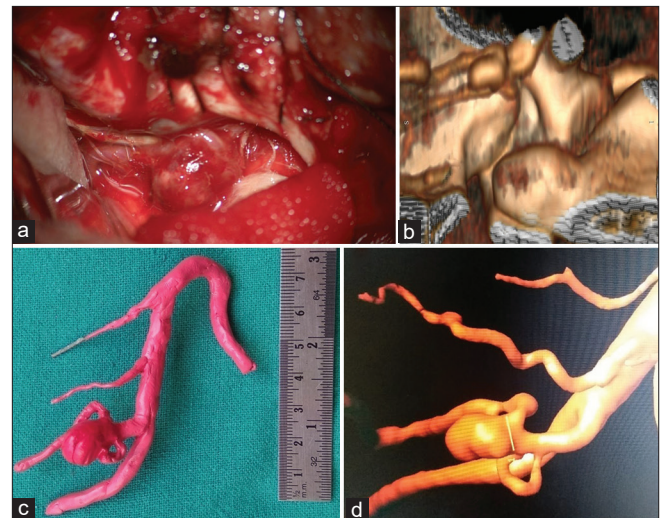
Surgically exposed left posterior inferior cerebellar artery aneurysm using left para-median suboccipital craniotomy (a). Same aneurysm seen on edited CT volume rendering technique (VRT) image (b), handmade model (c), digital subtraction angiography VRT, and (d) positioned similar to patient's head.
